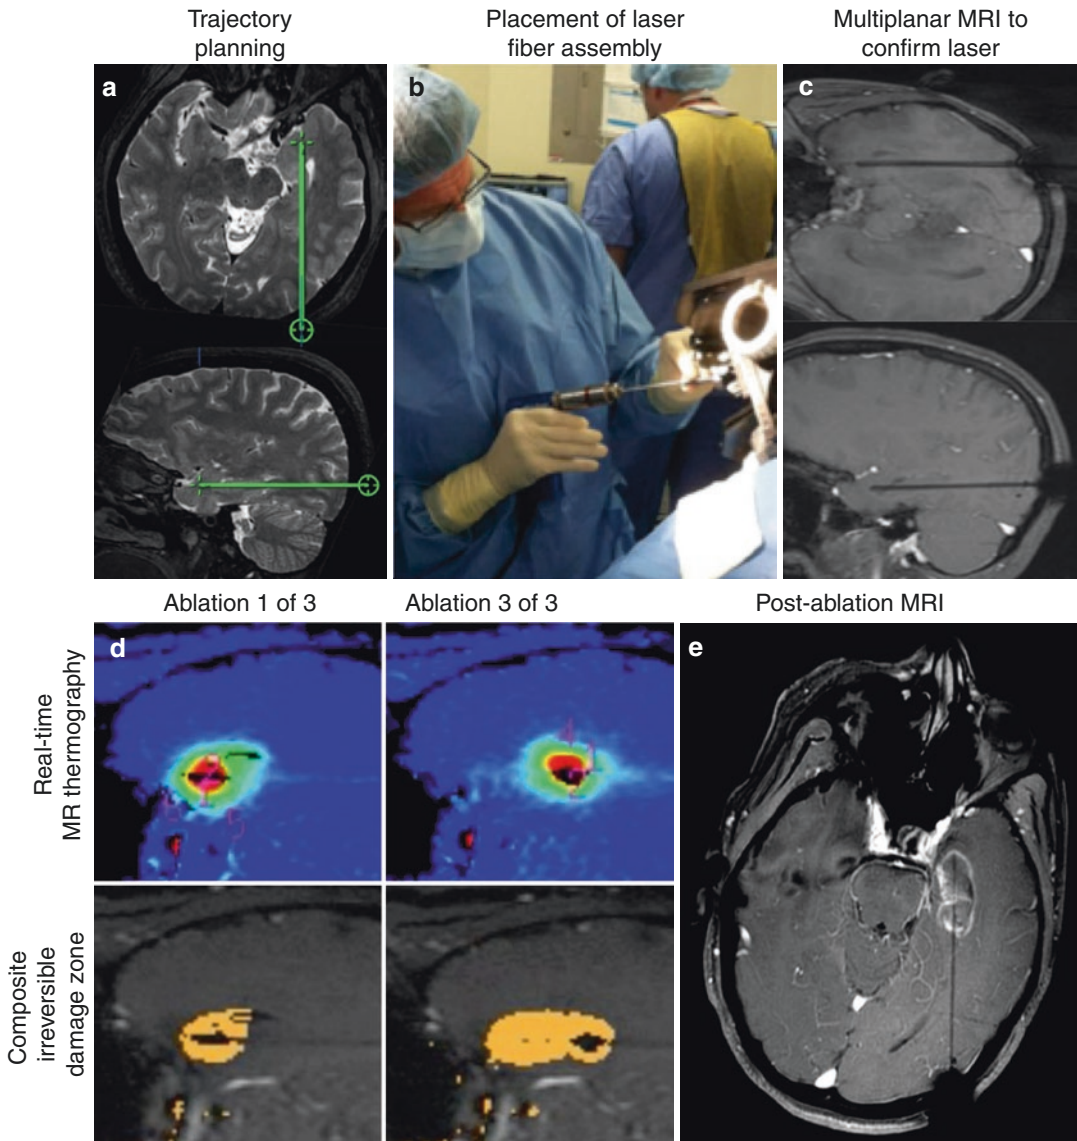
Stereotactic laser amygdalohippocampotomy procedure. The laser cannula trajectory is planned with the laser entering in the occipital lobe and traveling down the long axis of the amygdalohippocampal complex (a). The laser fiber assembly is then placed under stereotactic guidance (b). The patient is transported to MRI to obtain multiplanar cuts of the laser fiber assembly. This confirms proper placement and defines planes for temperature monitoring (c). Ablation is performed under real-time
